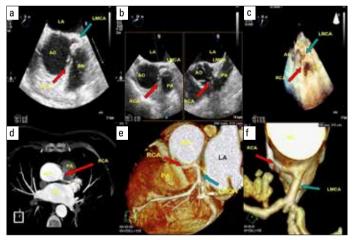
a) TEE image from 35° upper esophageal level shows an anomalous origin of the right coronary artery from the left sinus of Valsalva, b) TEE image from 20° upper esophageal level shows an anomalous origin of the right coronary artery from the left sinus of Valsalva and courses between the aorta and the pulmonary artery, c) 3D RT TEE shows an anomalous origin of the right coronary artery from the left sinus of Valsalva and courses between the aorta and the pulmonary artery, d) Coronary CT angiography axial image show that RCA originates from left sinus Valsalva with LMCA and courses between ascending aorta and pulmonary artery, e and f) Coronary CT angiography volume-rendering images show that RCA originates from left sinus Valsalva with LMCA and courses between ascending aorta and pulmonary artery, e and f) Coronary CT angiography volume-rendering images show that RCA originates from left sinus Valsalva with LMCA and courses between ascending aorta and pulmonary artery, e and f) Coronary CT angiography volume-rendering images show that RCA originates from left sinus Valsalva with LMCA and courses between ascending aorta and pulmonary artery e and f) Coronary CT angiography volume-rendering images show that RCA originates from left sinus Valsalva with LMCA and courses between ascending aorta and pulmonary artery e and f) Coronary CT angiography volume-rendering images show that RCA originates from left sinus Valsalva with LMCA and courses between ascending aorta and pulmonary artery e and f) Coronary CT angiography volume-rendering images show that RCA originates from left sinus Valsalva with LMCA and courses between ascending aorta and pulmonary artery e and f) Coronary CT angiography volume-rendering images show that RCA originates from left sinus Valsalva with LMCA and courses between ascending aorta and pulmonary artery e and f) Coronary CT angiography volume-rendering images show that RCA originates from left sinus Valsalva with LMCA and courses between ascending aorta and pulmonary artery e angiog
